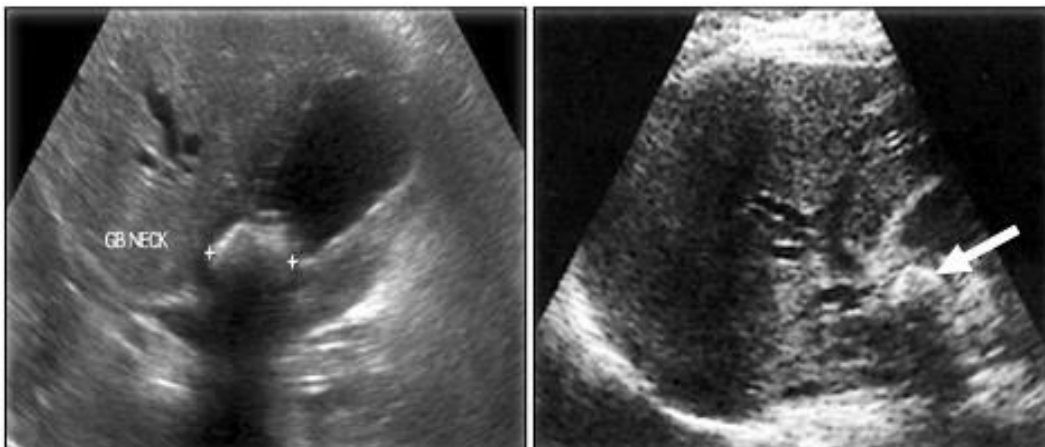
Ultrasound on Mirizzi syndrome.²¹
